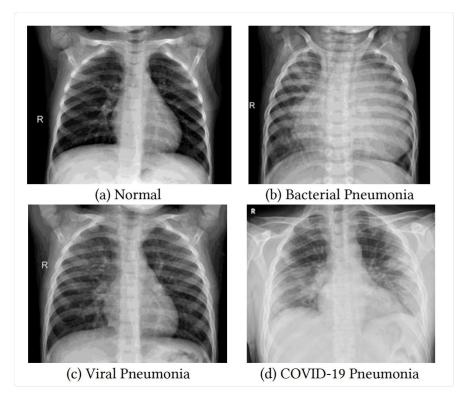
An idealized comparison of chest x-rays caused by different conditions [5]
